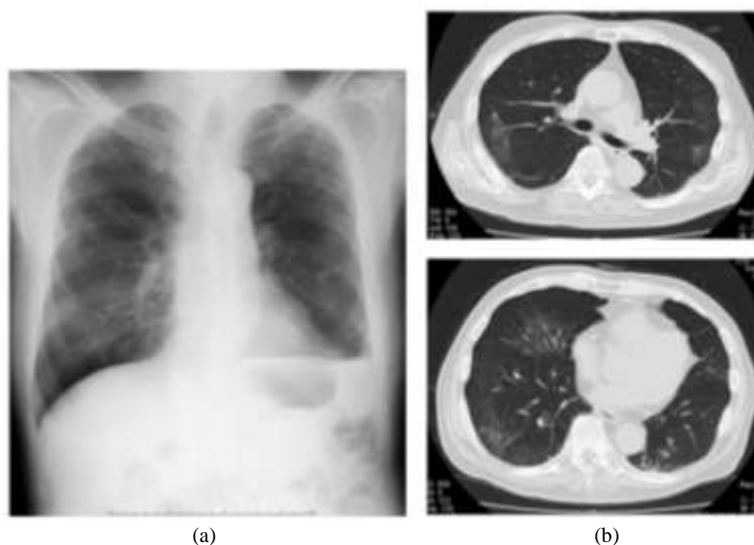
Chest X-ray and chest CT at the conclusion of antifungal therapy revealed the improvement of infiltration shadows
